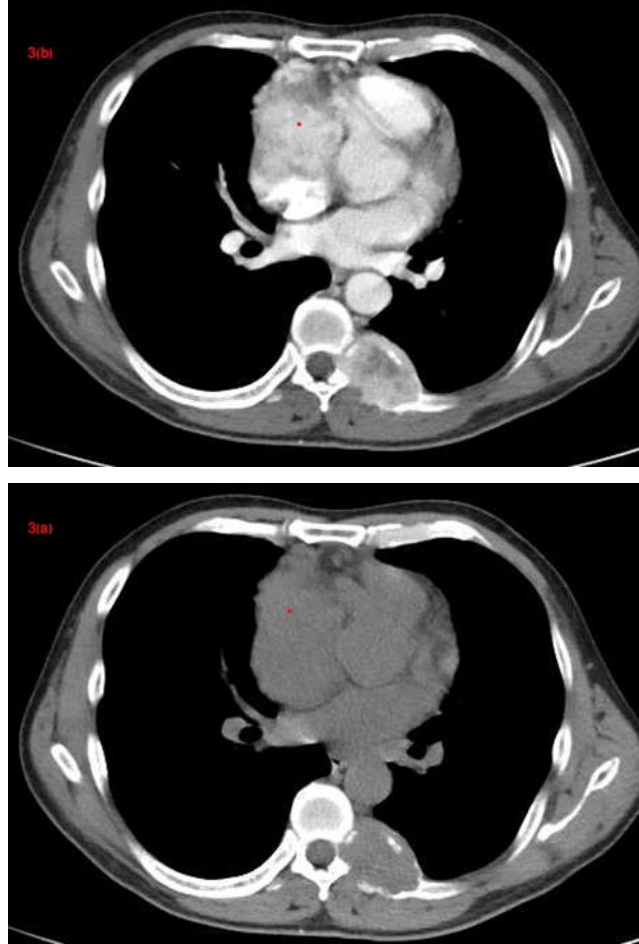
CT plain scan showed destruction of the left eighth rib bone and formation of soft tissue mass. On contrast-enhanced scan, the mass showed obvious heterogeneous enhancement.
